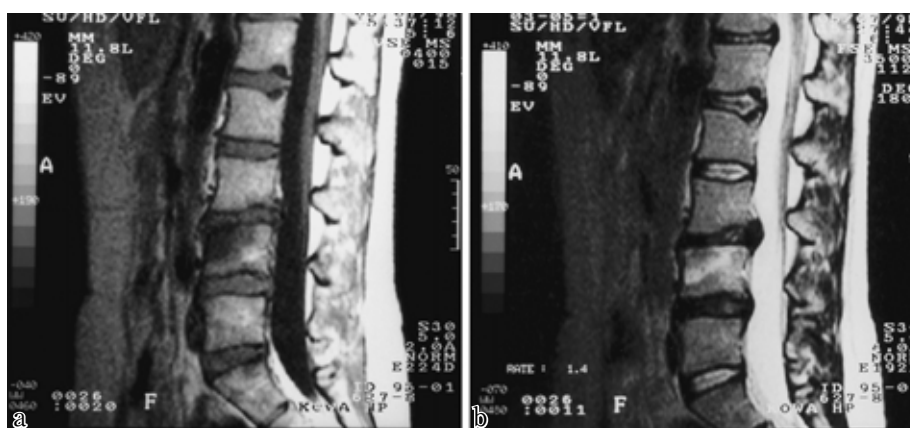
MRI at first visit to our hospital. MRI demonstrates abnormal signal intensity in antero-superior portion of L 4 vertebral body (low signal intensity in T 1 weighted image, high signal intensity in T 2* weighted image) suggesting inflammatory lesion
